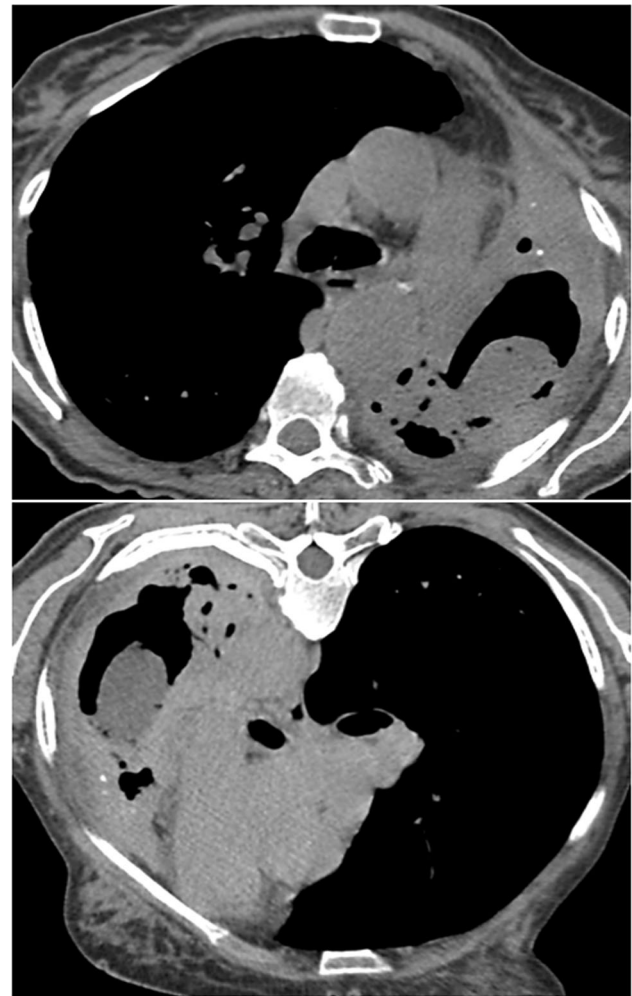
Aspergilloma. A 62-year-old woman with a previous history of tuberculosis. Axial CT image obtained with mediastinal window settings. a Show a thick-walled cavity containing an ovoid mass in the left upper lobe of the lung. b An image obtained with the patient in the prone position demonstrates the change in the aspergilloma location
